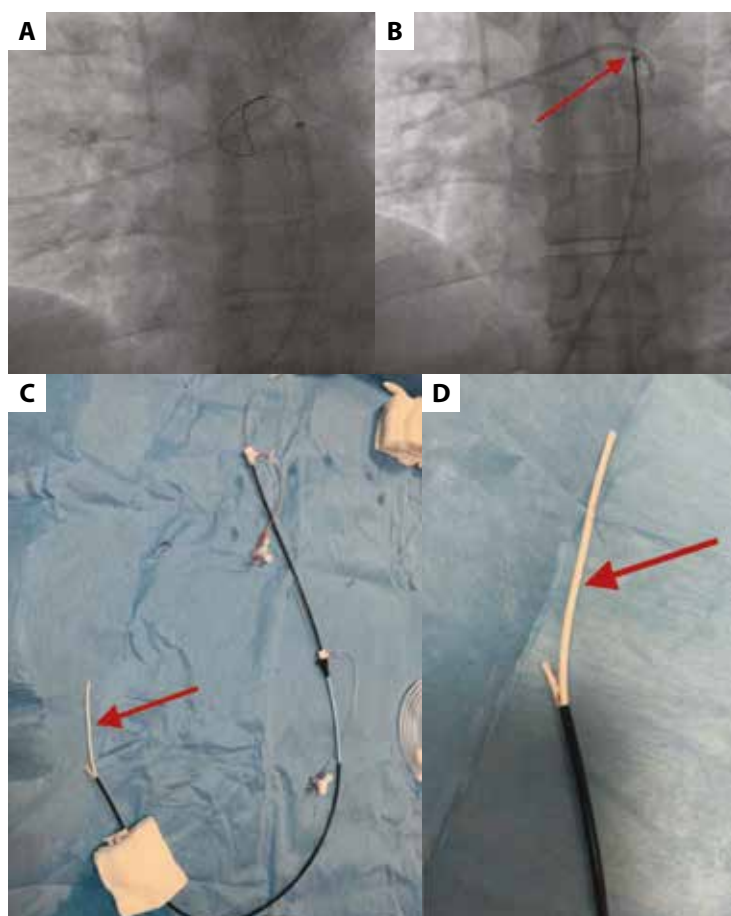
A and B. Chest X-ray obtained in the catheterization laboratory. A. 7F 90 cm sheath (Cook Medical) inserted into the right pulmonary artery via the right femoral. B. Removal of the detached port fragment using a large capture capacity snare (Exeter Snare 15; red arrow). C and D. The detached port fragment after externalization (red arrows). C. Vascular sheath 7F 90 cm (Cook Medical) with the retrieved port fragment (red arrow). D. The retrieved fragment captured by a snare (Exeter Snare 15; red arrow)
